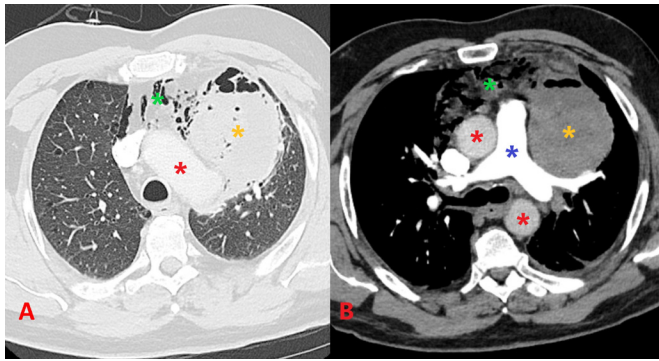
Chest CT scan revealing a large, heterogeneous lesion emerging from the aortopulmonary window (yellow asterisk) associated with pneumomediastinum and extensive mediastinal infiltration, suggesting severe mediastinitis (green asterisk). Note the proximity of the lesion to the aorta (red asterisk) and the pulmonary trunk (blue asterisk).
